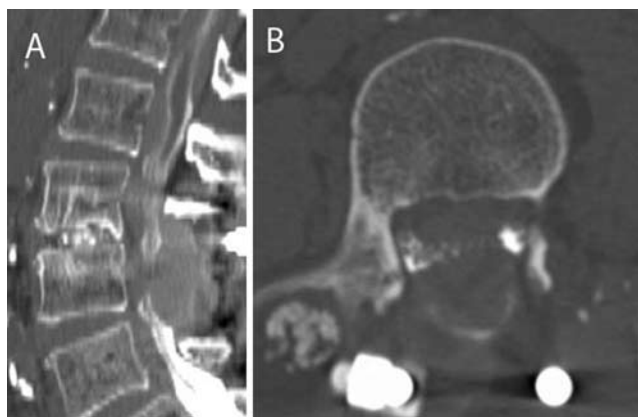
Case 1. Sagittal (A) and axial (B) CT myelograms reveal an intradural compression of the neural elements by an arachnoid cyst, which extends up into the lower thoracic spine.
